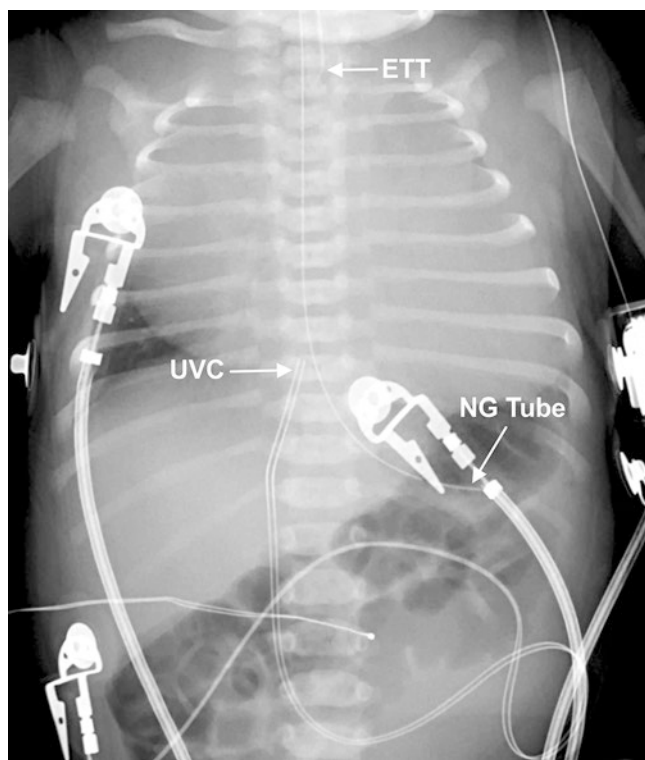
Radiograph in a neonate with congenital heart disease displaying massive cardiomegaly. The position of the tip of the endotracheal tube (ETT) appears high, prompting readjustment. The nasogastric (NG) tube is in the stomach and the tip of the umbilical venous catheter (UVC) is in good position at the inferior vena cava to right atrial junction
